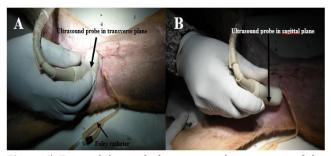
Trans-abdominal ultrasonographic scanning of the urinary bladder in transverse (A) and sagittal (B) planes.
